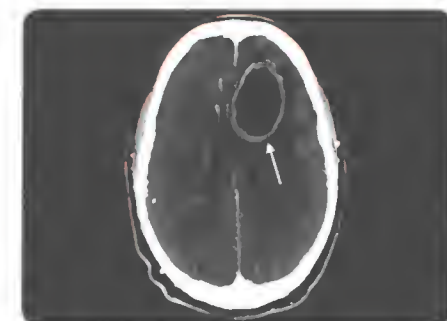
Axial section of computed tomography scan showing brain abscesses involving the left parietal region (arrow)
